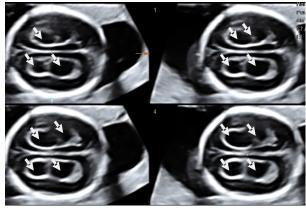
Choroid plexus cysts (arrow). Tomographic Ultrasound Imaging (TUI).
